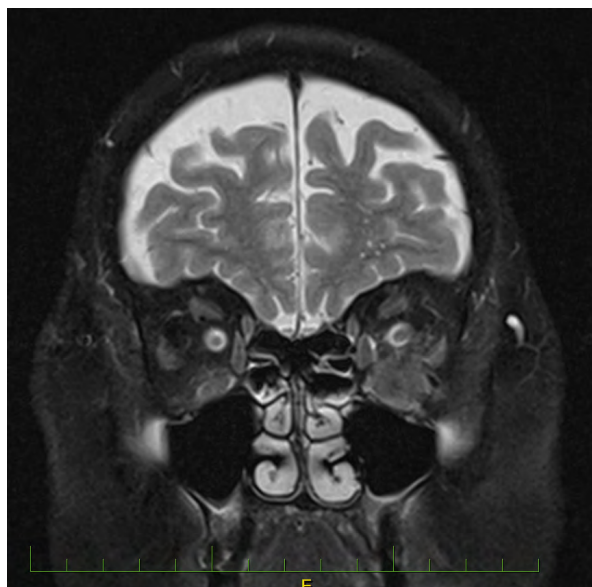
Magnetic resonance image of metastasis from breast cancer, coronal view
